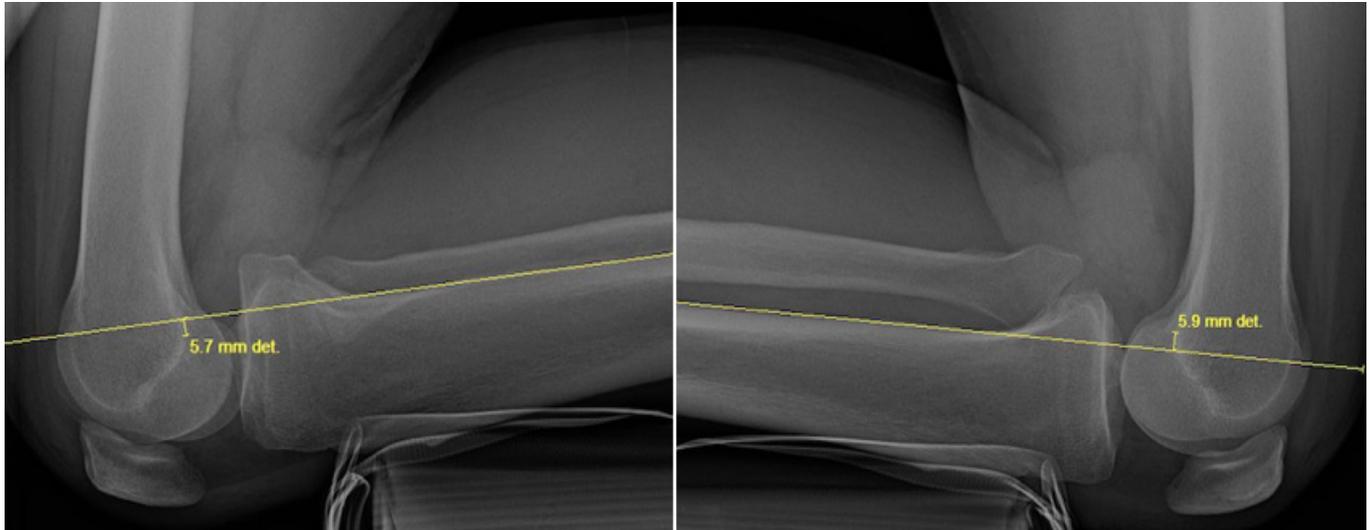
Lateral kneeling posterior stress radiographs that demonstrate an increase of 11.6 mm of posterior translation between the injured and uninjured knee. A line is extended parallel from the posterior cortex from at least 15 cm distal to the joint line. A perpendicular line is drawn from this line to the posterior point of the Blumensaat line and the distance is measured and recorded for each knee. The difference between these two points is the posterior tibial translation distance. (*Jackman T, LaPrade RF, Pontinen T, Lender PA. Intraobserver and interobserver reliability of the kneeling technique of stress radiography for the evaluation of posterior knee laxity. Am J Sports Med. 2008;36:1571-1776.*)
